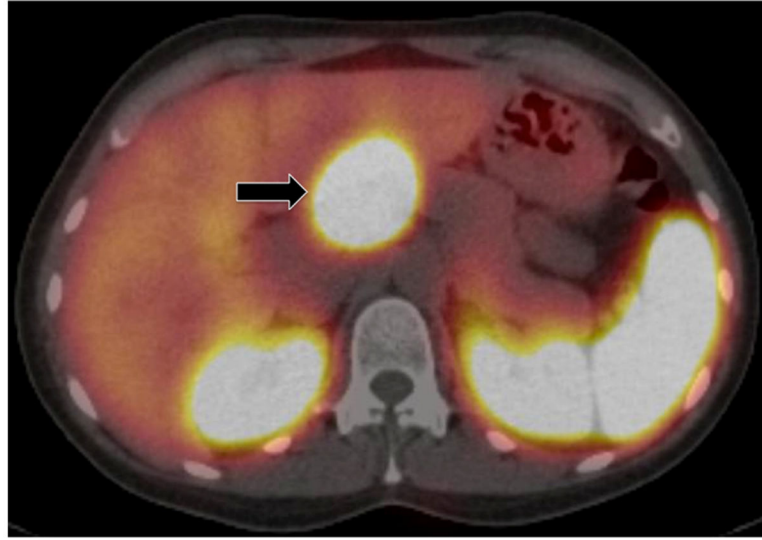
Octreoscan fused with SPECT/CT
